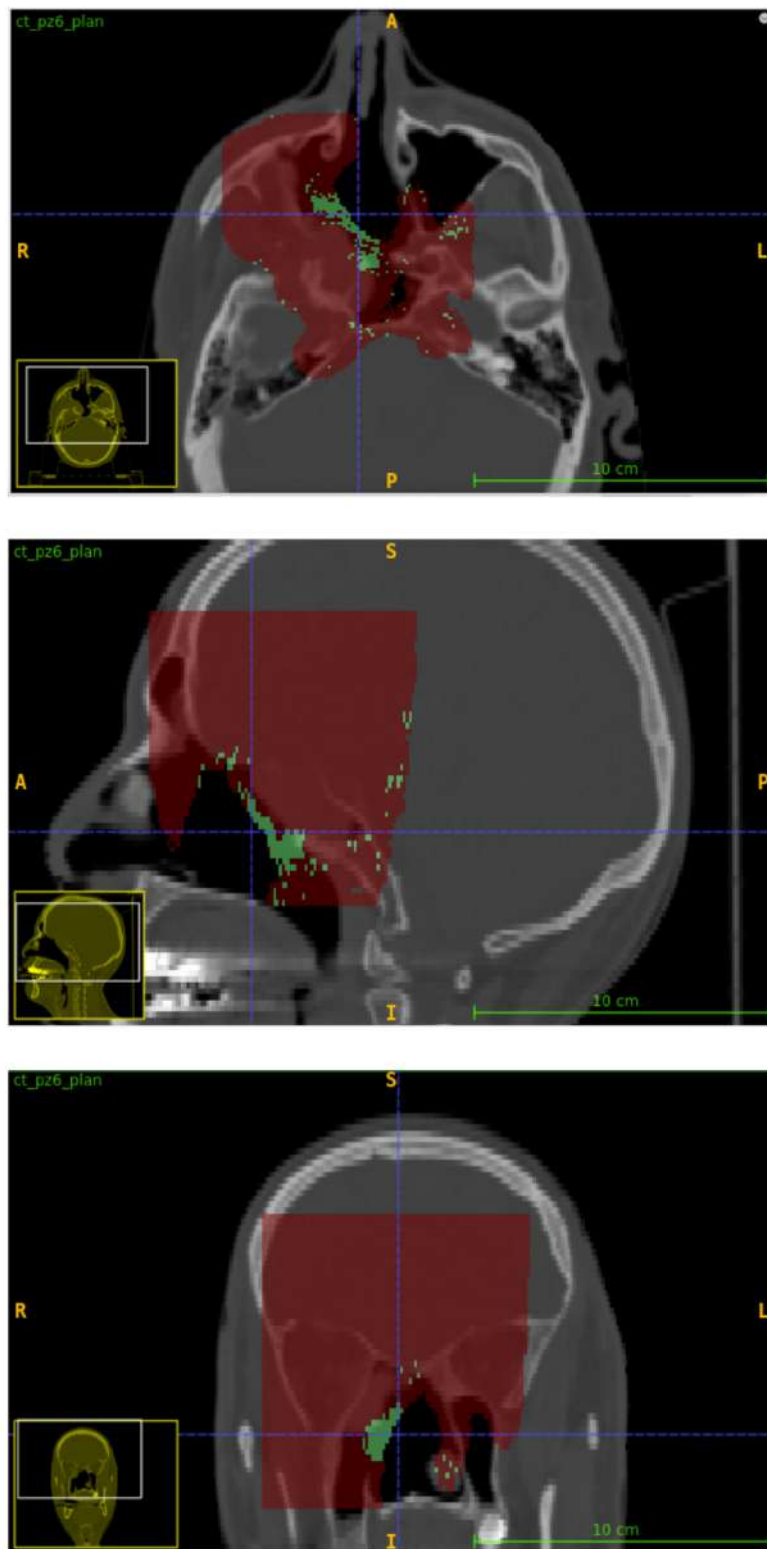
Pass rate map for  $DD = 45\%$ ,  $DTA = 4 \text{ mm}$ ,  $DTH = 0.5\%$  in axial, sagittal and coronal views (from top to bottom), overlaid on the planning CT.
